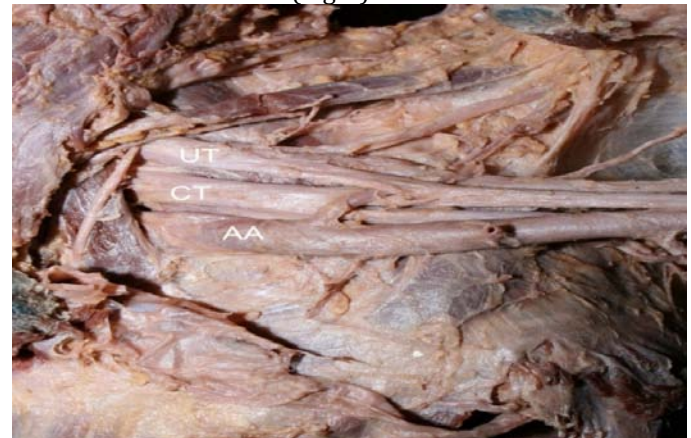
Shows the normal upper trunk and the common trunk with axillary artery. UT- Upper trunk, CT- Common trunk, AA- Axillary Artery.
